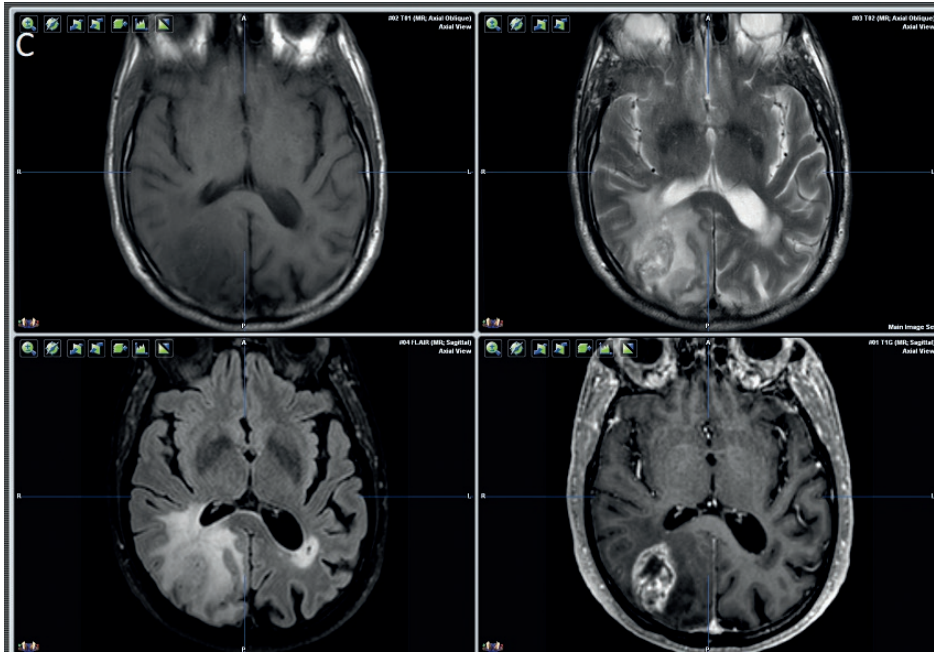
Examples of standard MRI for different glioma subtypes
